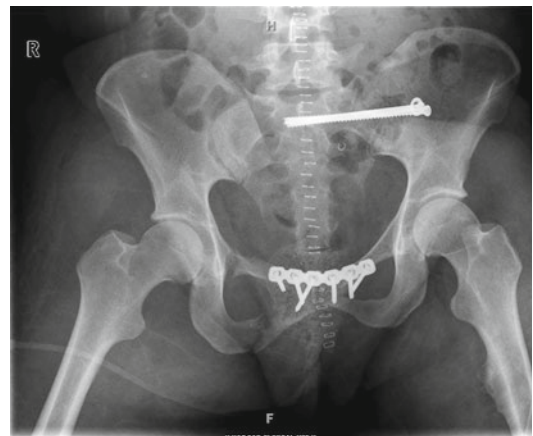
An AP pelvis X-ray after anterior ring fixation and placement of two left iliosacral screws to stabilize the posterior ring
